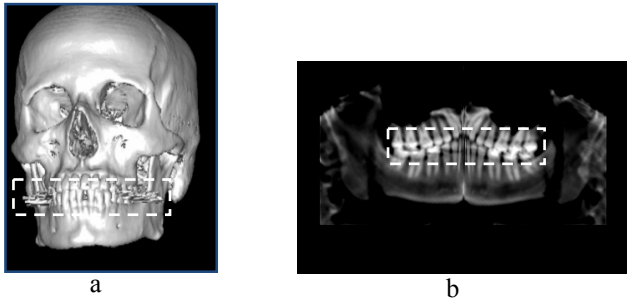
Filling materials noises; (a) 3D model for a mandible as a part of a skull, (b) panoramic x-ray, the White dashed rectangles refers to the filling cavity material that cause the noise.
